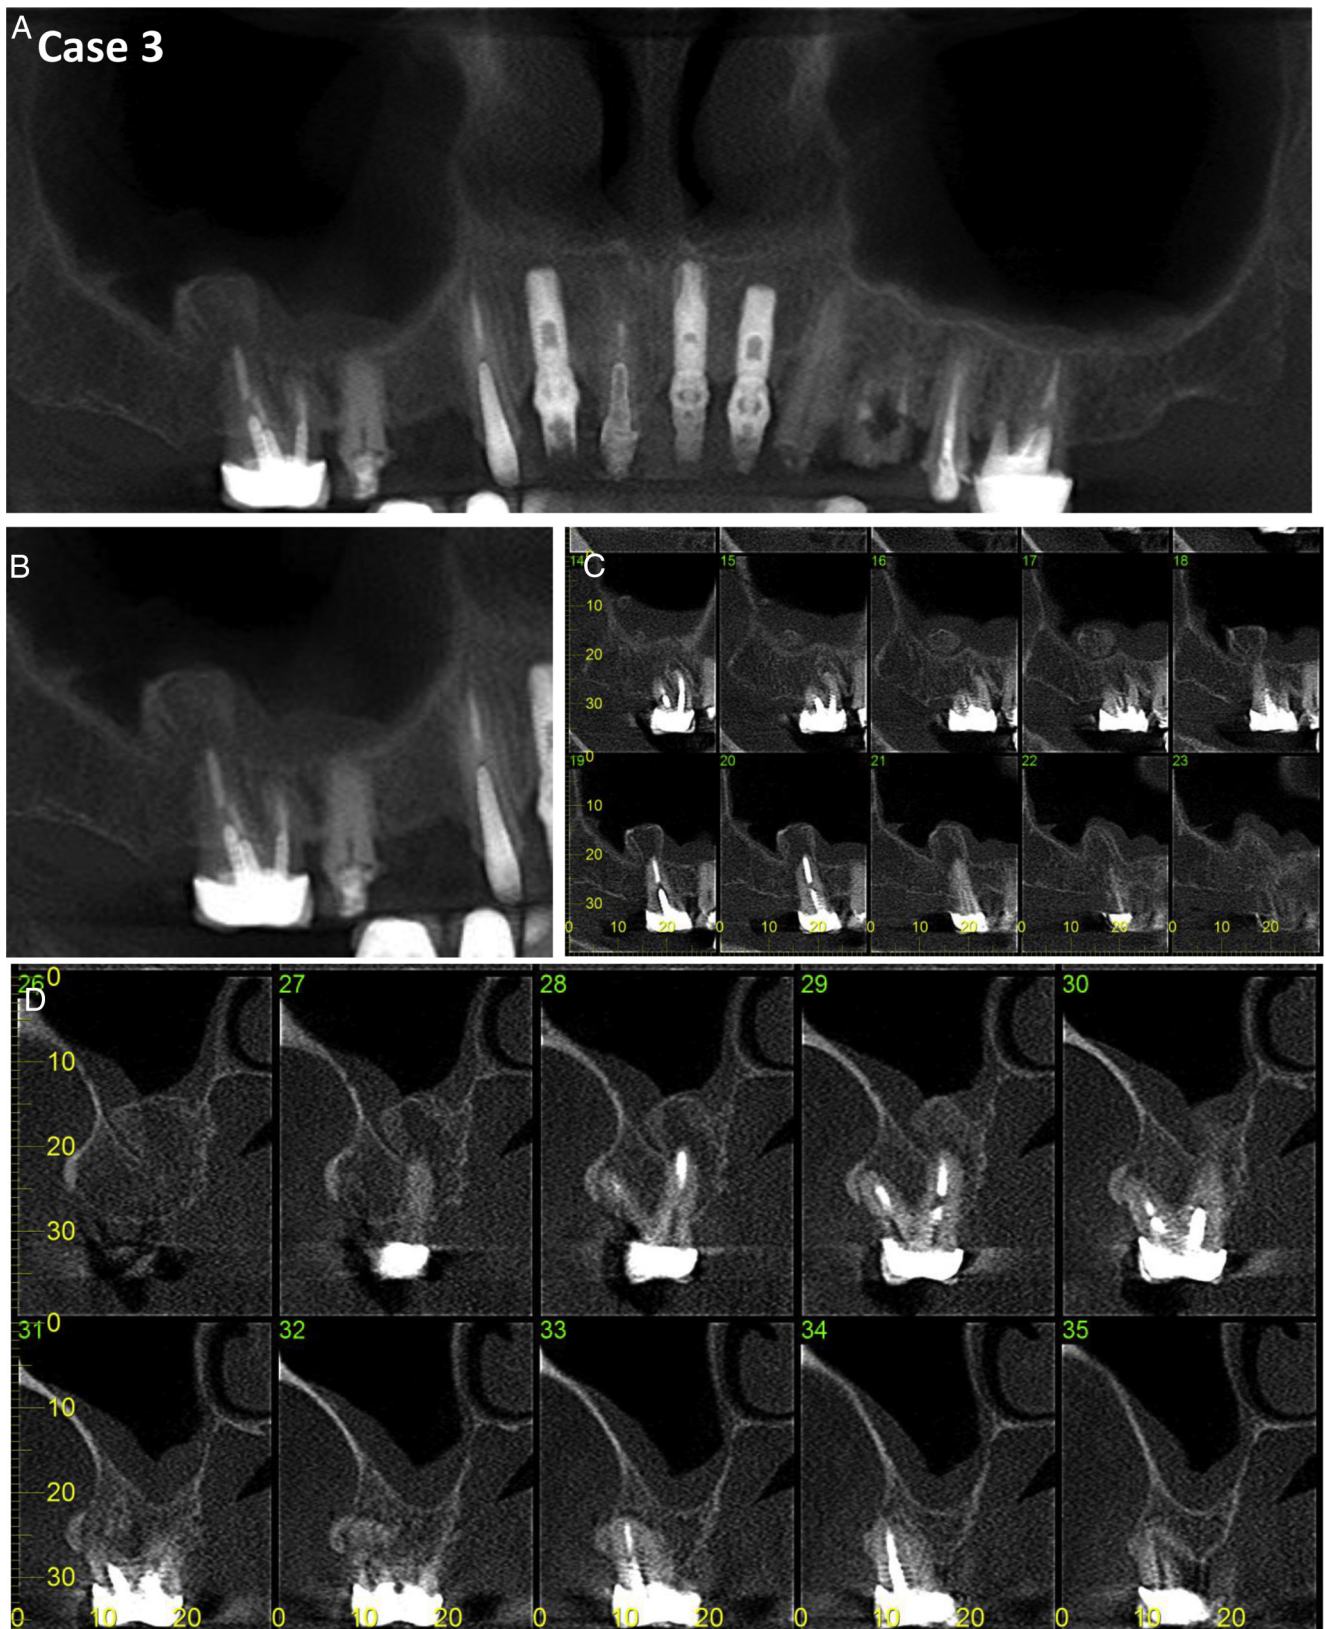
(A) A panoramic view shows well-defined hypodense periapical lesion associated with a heterogeneous hyperdense oval structure near tooth #3. (B–D) CBCT scan shows periapical lesion associated with lingual root of tooth #3 projecting into the MS.
